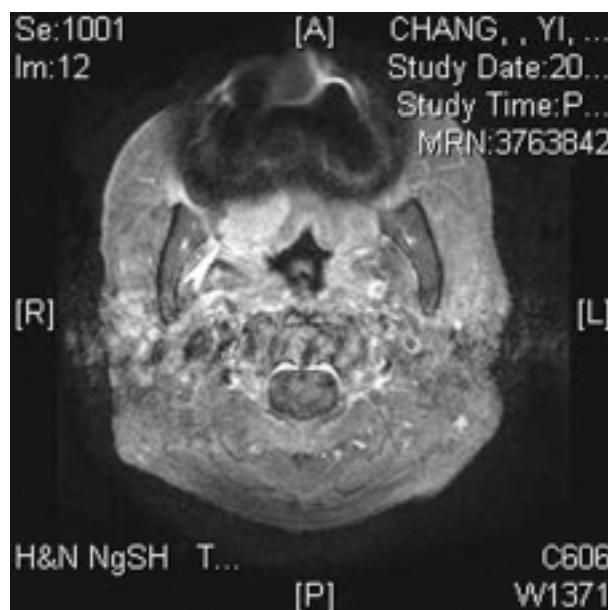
MRI exam showed a hyperintensive heterogeneous enhancement tumor at lateral and posterior portion of right tongue on T1W1 image.
